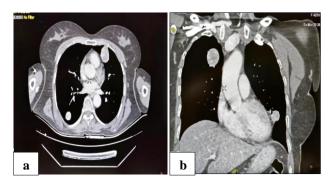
(a and b): HRCT thorax showing enhancing nodular lesions involving both lungs largest measuring 2.35 cm along with fibrosis.
